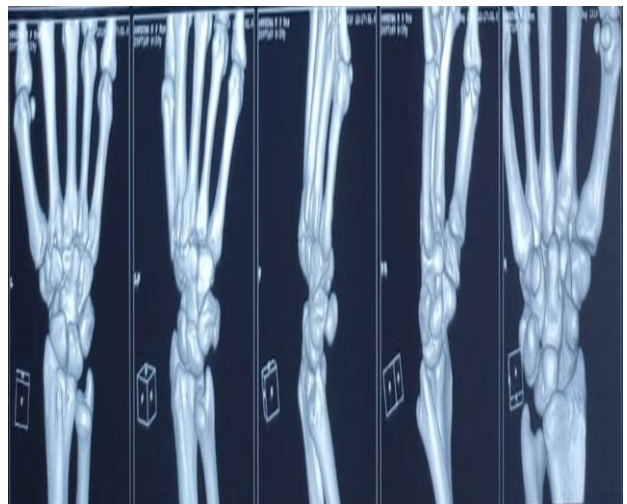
CT 3d reconstruction of wrist showing bony outgrowth over the capitate.
